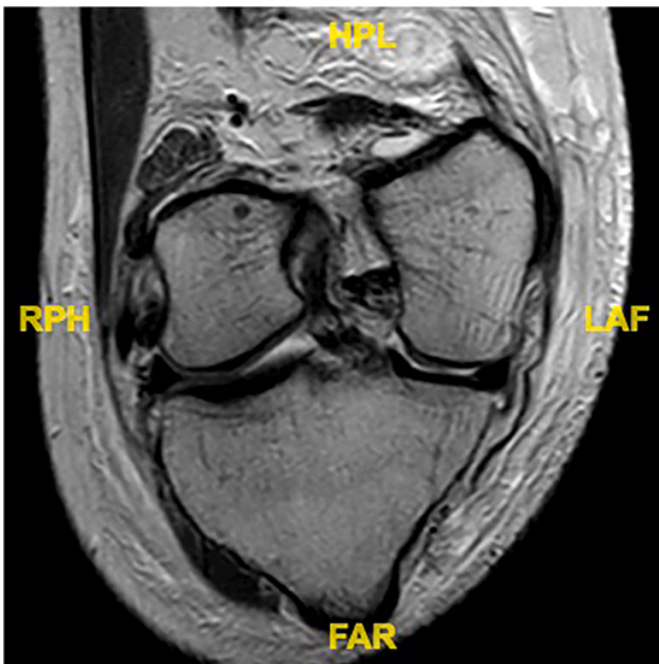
Coronal oblique T2-weighted MRI confirming ACL middle third injury.
